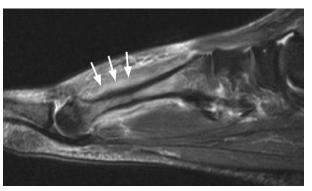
Thirty-seven year-old female golfer with the forefoot pain. T2-weighted sagittal MRI showing an isolated stress fracture of the 2nd metatarsal shaft with the marrow edema, cortical thickening due to reparative new bone formation (arrows) and a moderate degree of juxtacortical edema. This fracture was apparent on radiographs. MRI was requested to rule out concominent injury in view of unremitting symptoms. MRI indicates magnetic resonance imaging.
